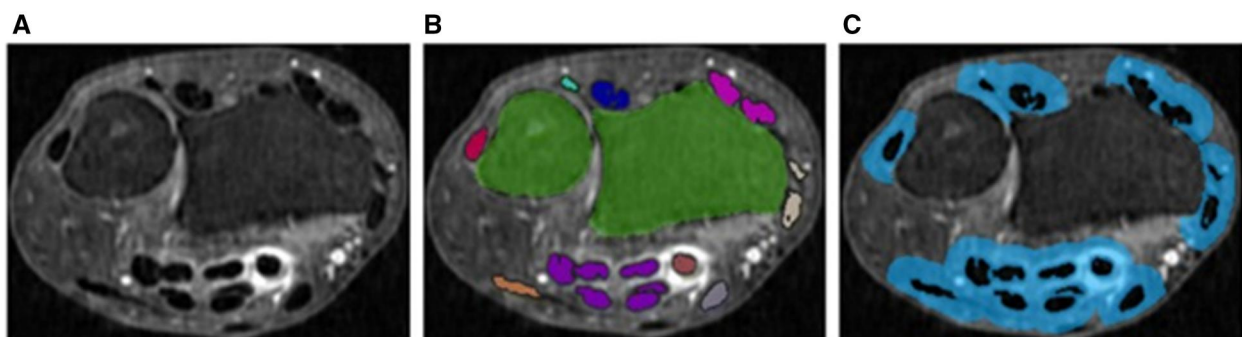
MRI scans of the wrist adapted from Aizenberg *et al.* [18]. This study is published under a CC-BY Creative Commons license. (A) A supersolution reconstruction (SRR) image of the wrist, (B) the segmented tendon regions and bones and (C) the area in which tenosynovitis is quantified
